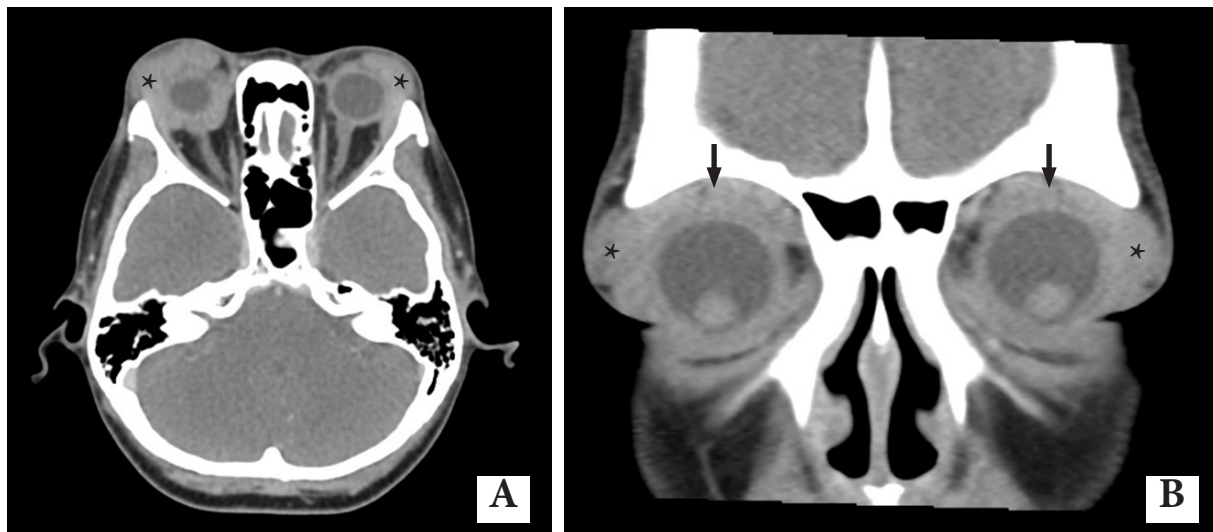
Conventional CT of the orbit in axial (A) and coronal (B) views show multiple enhancing masses involving both lacrimal glands (*), upper eyelids (arrow), and the intra/extra-conal spaces of both orbits. Pathology proven is extranodal marginal zone lymphoma of the mucosa-associated lymphoid tissue (MALT lymphoma).
